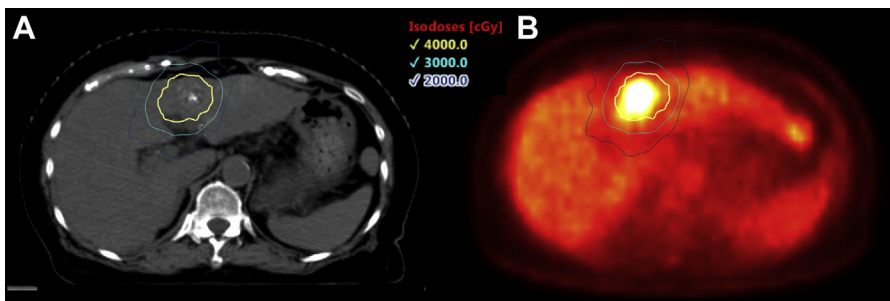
SBRT for HCC ineligible for transplantation. A 74-year-old woman with NASH cirrhosis developed a left liver lobe HCC with AFP of 736. She completed TACE followed by SBRT (4000 cGy in 5 fractions) in March, 2016. (A) SBRT plan on planning CT. Isodose lines represented in absolute dose (cGy). (B) SBRT plan projected on pretreatment PET, which demonstrated an FDG (Fluorodeoxyglucose [¹⁸F]) avid HCC. The patient's AFP normalized by 6 months post-treatment and has remained in the normal range.
